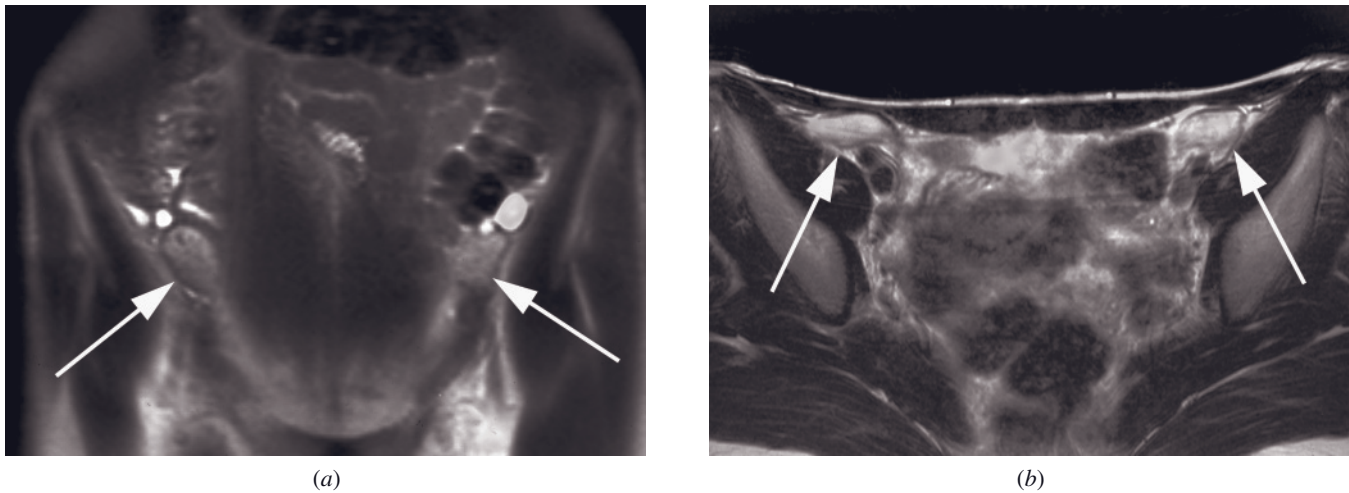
Testicular feminization. Coronal T2-weighted SS-ETSE (a) and transverse (b) T2-weighted ETSE images in a patient with complete androgen insensitivity. The uterus is absent. Bilateral rounded structures (arrows, a, b) with no follicles are seen at the internal inguinal ring, representing testes.
